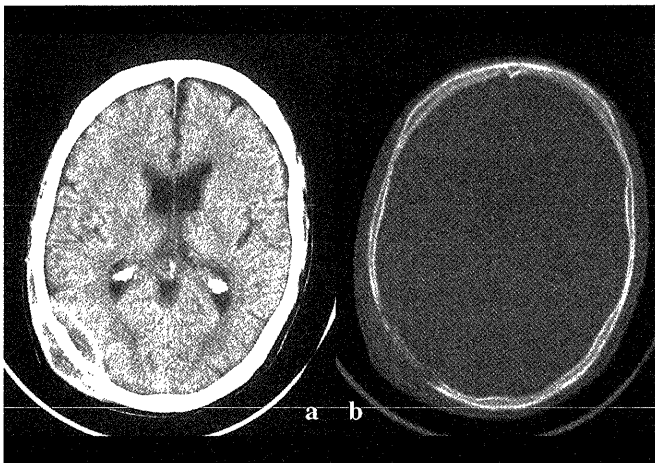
a: Non-enhanced transverse CT scan of the head showing a mass formation in both the inner and outer tables of the cranial bone. b: Different window setting of the same slice better showing lytic changes of the parietal bone.
